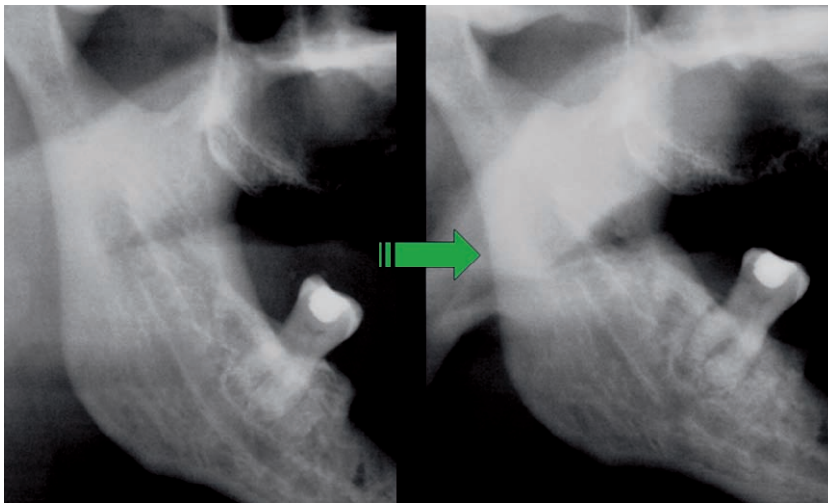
Details from panoramic radiographs. Progress of osteoradionecrosis 6 months (*left*) and 2 years (*right*) following radiation therapy. Note increased dimensions of patches of sclerotic bone and widening of the periodontal ligament space around the mandibular molar over the follow up period
